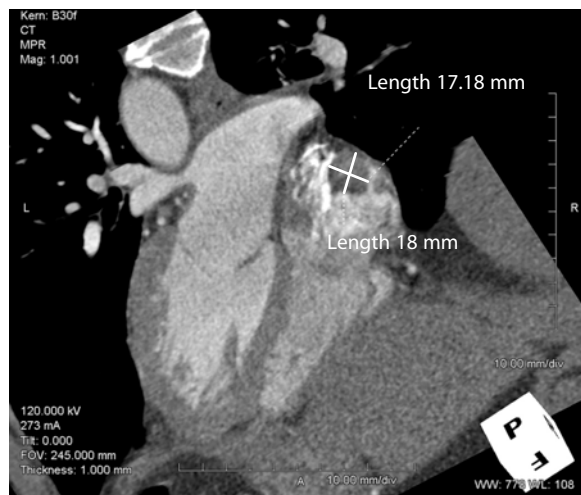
MPR image and dimensions of a right atrial thrombus. Data were obtained using 16-slice CT with 16×0.75 -mm collimation and 0.42-s rotation time
